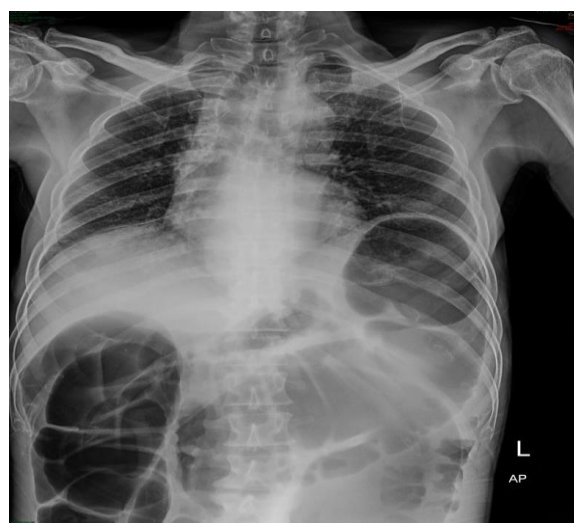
Chest X-ray. Cardio-pulmonary within normal limitation. No presence of free air in occurrences of perforation.
